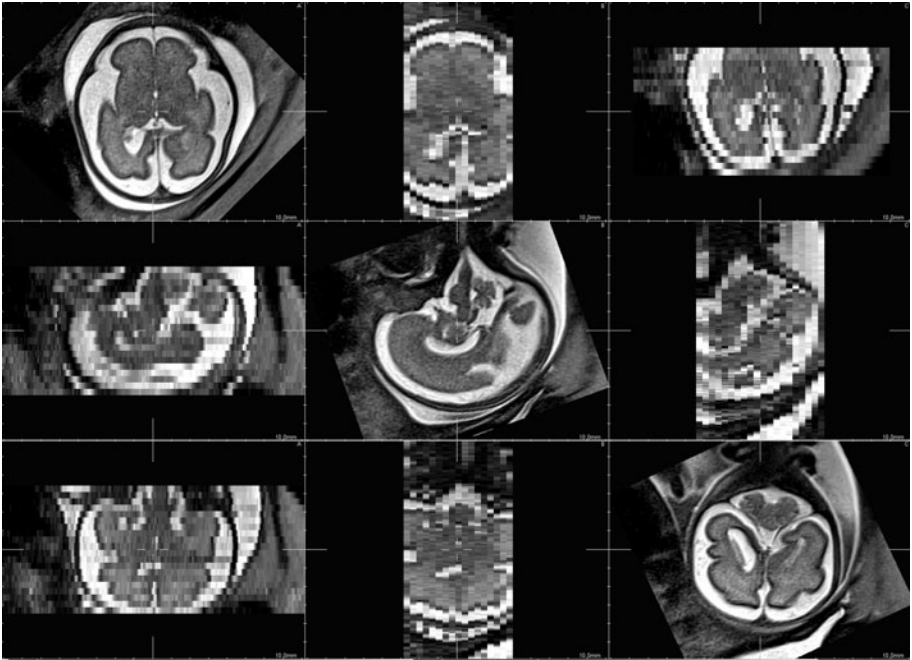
Acquired fetal MR image data with anisotropic resolution. It can be noted that the LR images provide complementary views of the entire brain. From left to right: 1) axial LR image, 2) sagittal LR image, 3) coronal LR image.
